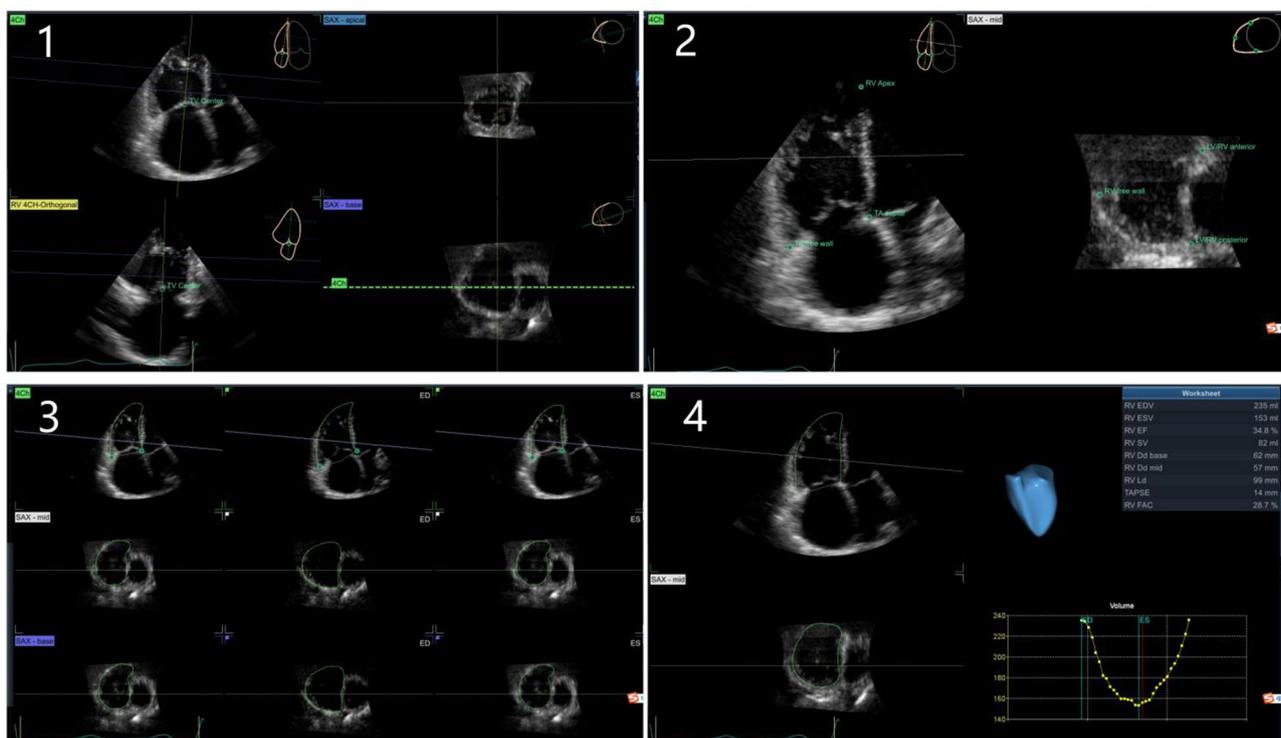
Postprocessing for quantification of RV volumes and function using offline 3D echocardiographic analysis software. (1) Data alignment to identify the RV long axis. (2) Define landmarks. (3) Software was used to automatically extract the 3D endocardial surface. (4) A 3D model of the RV was generated. RV: right ventricle; 4Ch: four-chamber view; SAX: short-axis
